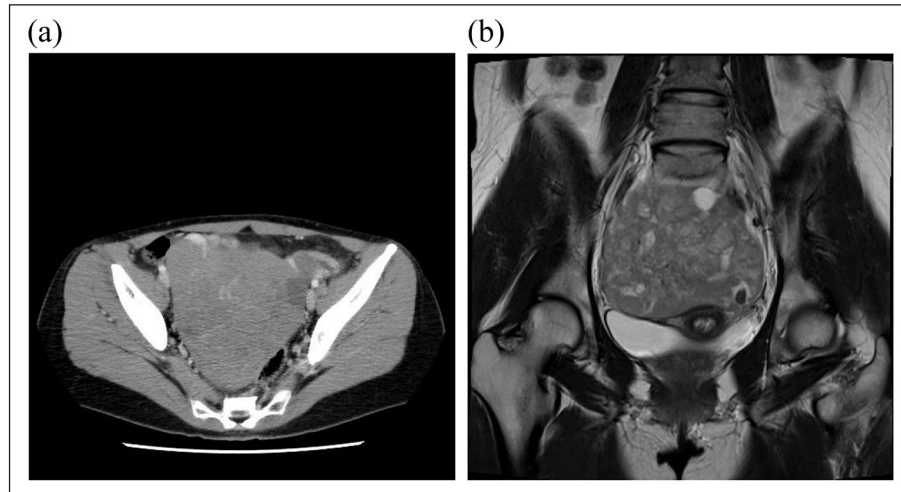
Imaging findings. (a) Computed tomography scan of abdomen. A large mass of approximately 12 cm occupies the pelvic cavity. Although the mass comprised mainly solid components, partially cystic components are also present. (b) Magnetic resonance imaging T2-weighted image shows a heterogeneous mass with no fat component.
